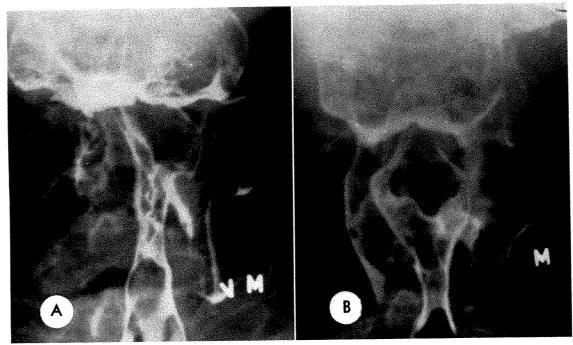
Case iv. (A) April, 1963: Positive contrast study done prior to roentgen-ray therapy. Frontal projection of ballooned pharynx in modified Valsalva maneuver (blowing against puffed cheeks). Left pyriform sinus distends normally. Right pyriform sinus not distensible and replaced by extensively ulcerated mass. (B) February, 1966: Positive contrast study in frontal projection of modified Valsalva maneuver done 2 years 8 months after completion of roentgen-ray therapy. No evidence of tumor recurrence. The right pyriform sinus is reformed and covered with smooth mucosa and has a moderate degree of distensibility.
